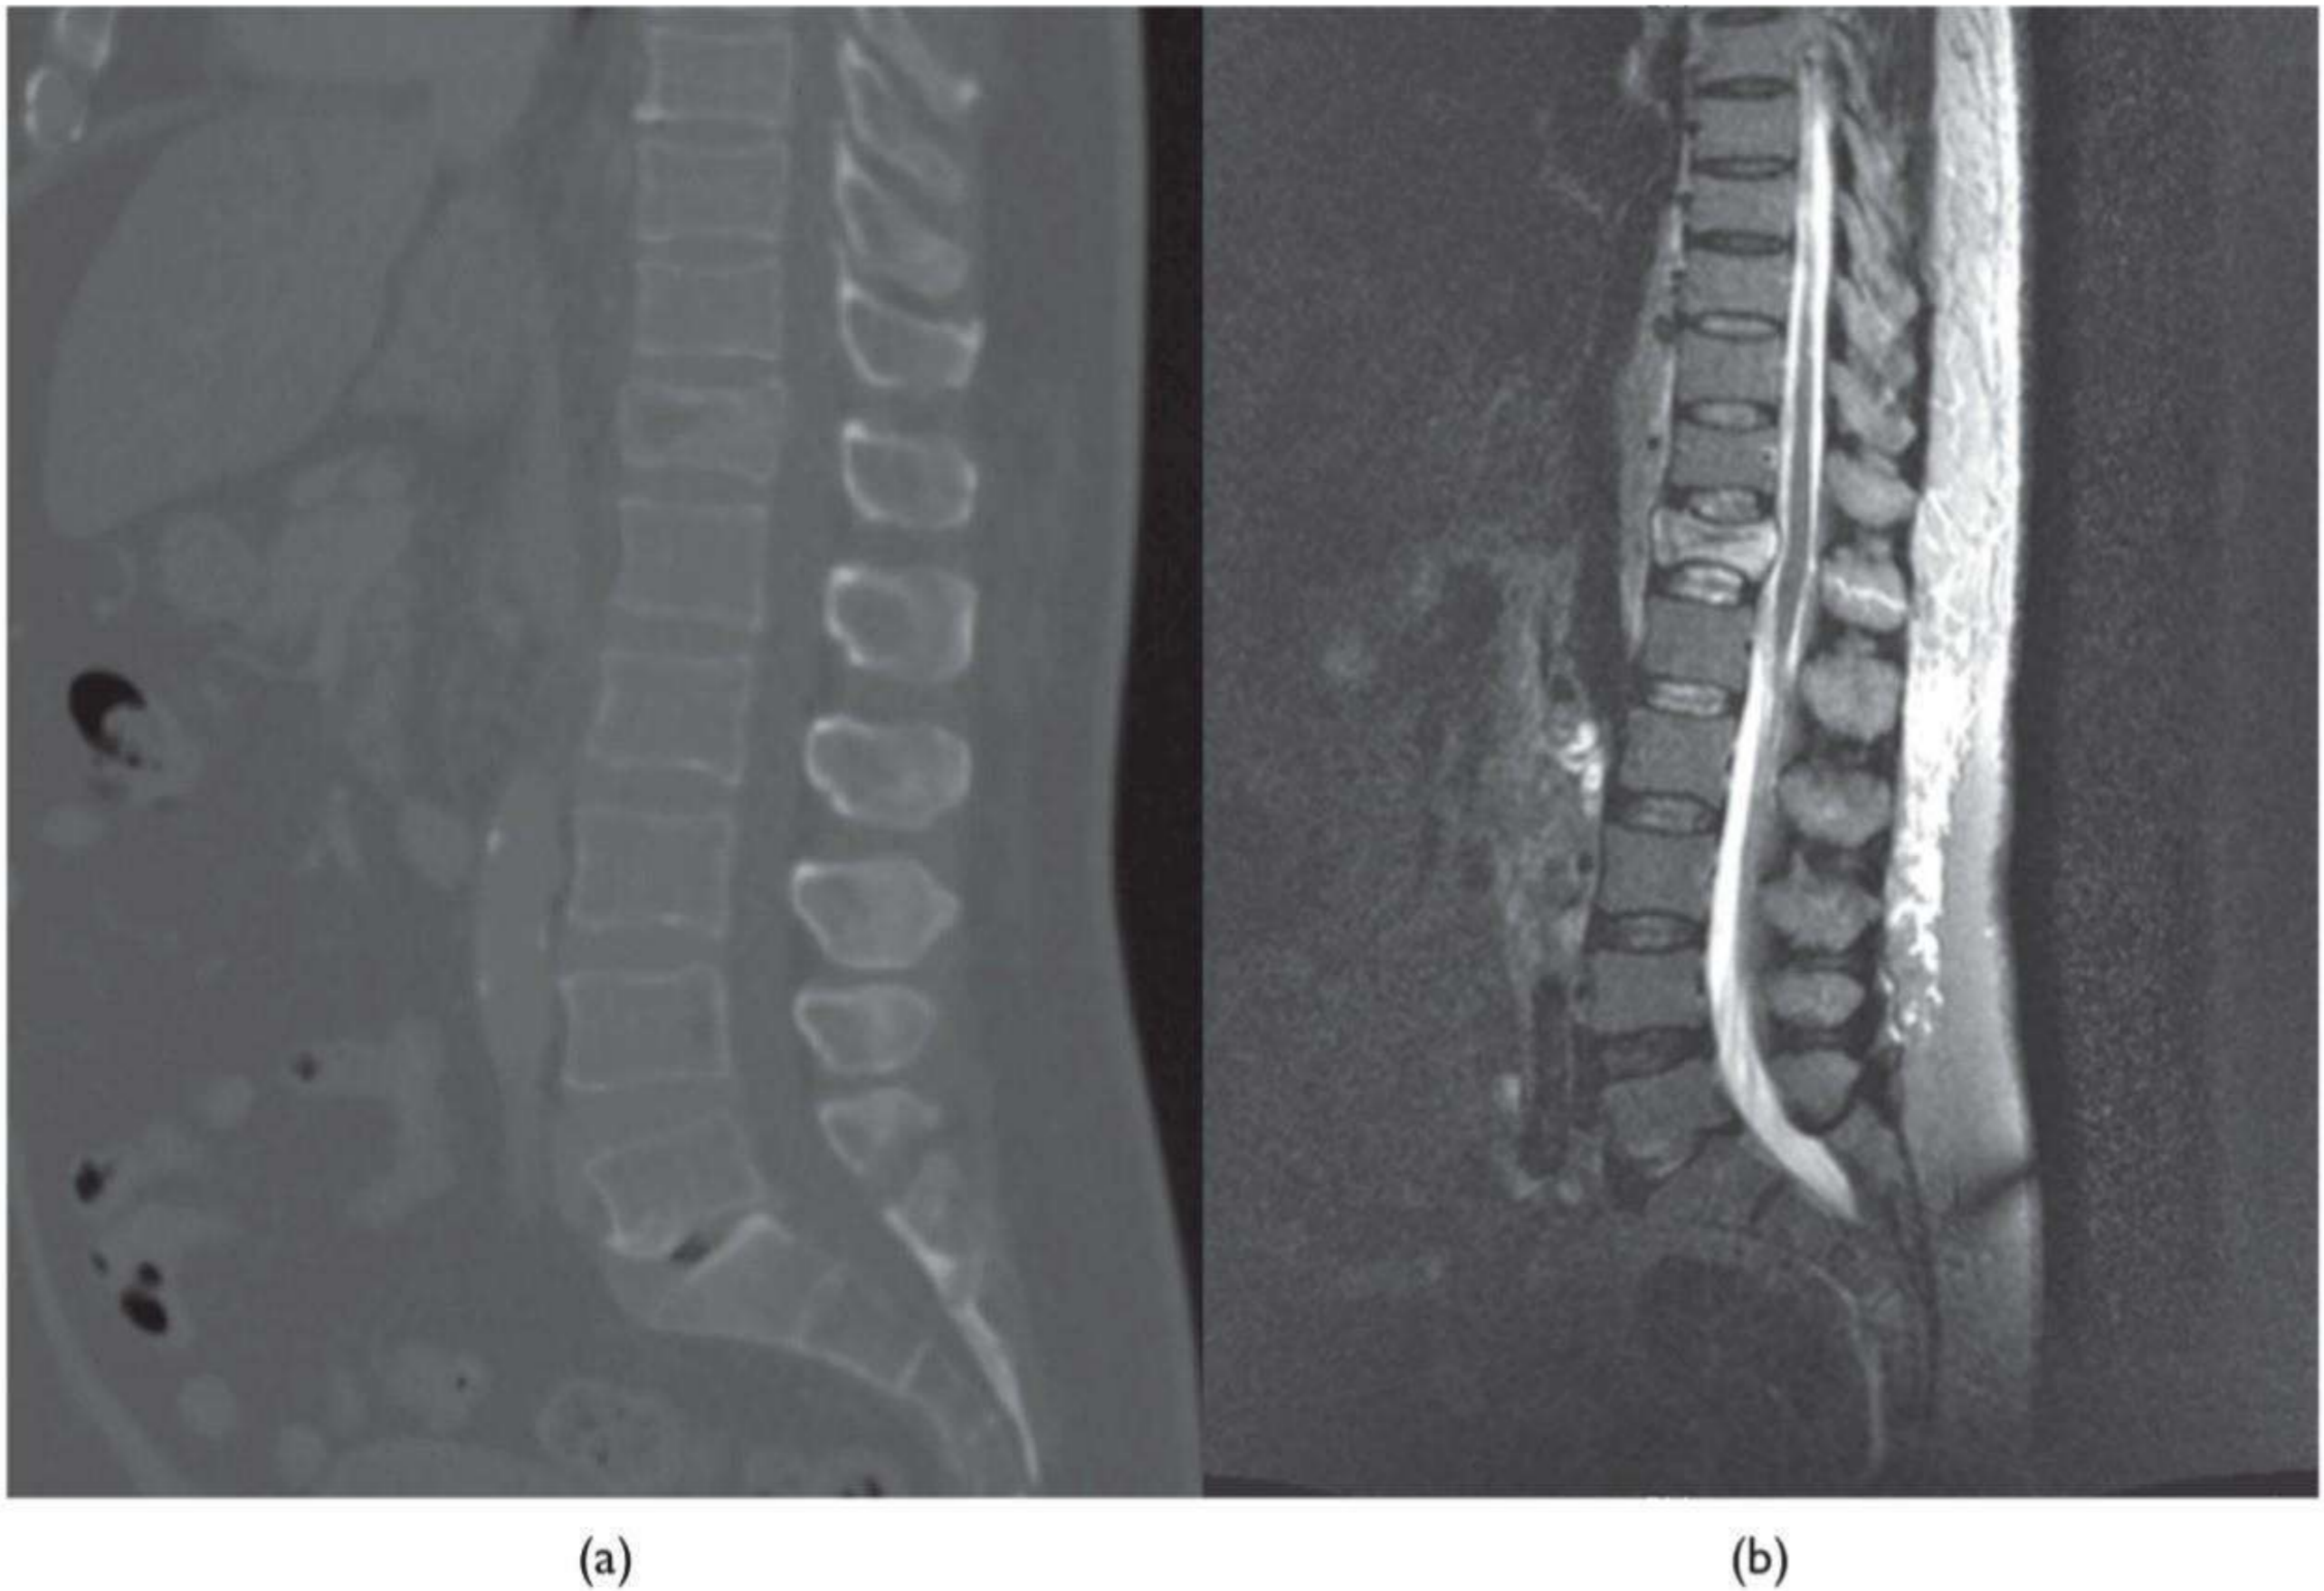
Lumbar spine CT (a) and MRI (b)
